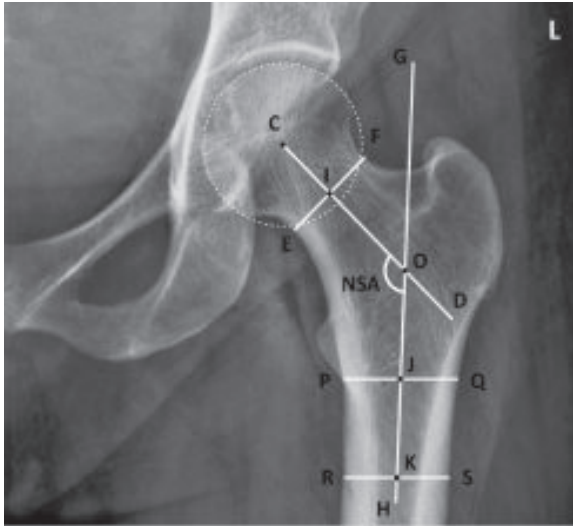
Plain digital radiograph of pelvis AP view showing measurement of femoral neck length (CO) and neck-shaft angle (NSA); C- femoral head center, CD- femoral neck axis, PQ- diameter of femoral shaft at the level of lower point of the lesser trochanter, RS- diameter of femoral shaft at 5cm distal to PQ, J- midpoint of PQ, K- midpoint of RS, GH- femoral Shaft axis, O- intersection of CD & GH
